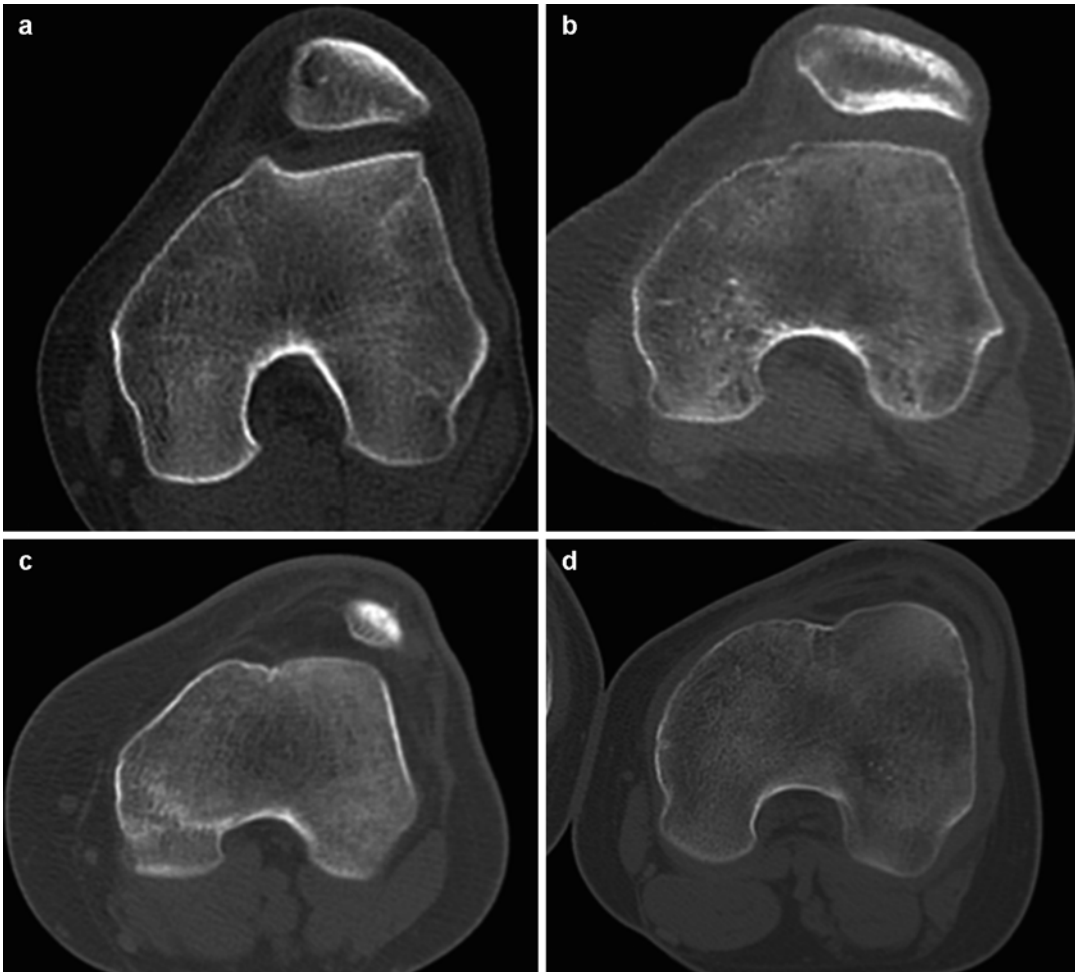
(a) Type A: normal morphology of both trochlear facets on CT scan. Trochlear angle $> 145^\circ$. (b) Type B: flat trochlea. (c) Type C: medial facet hypoplasia
